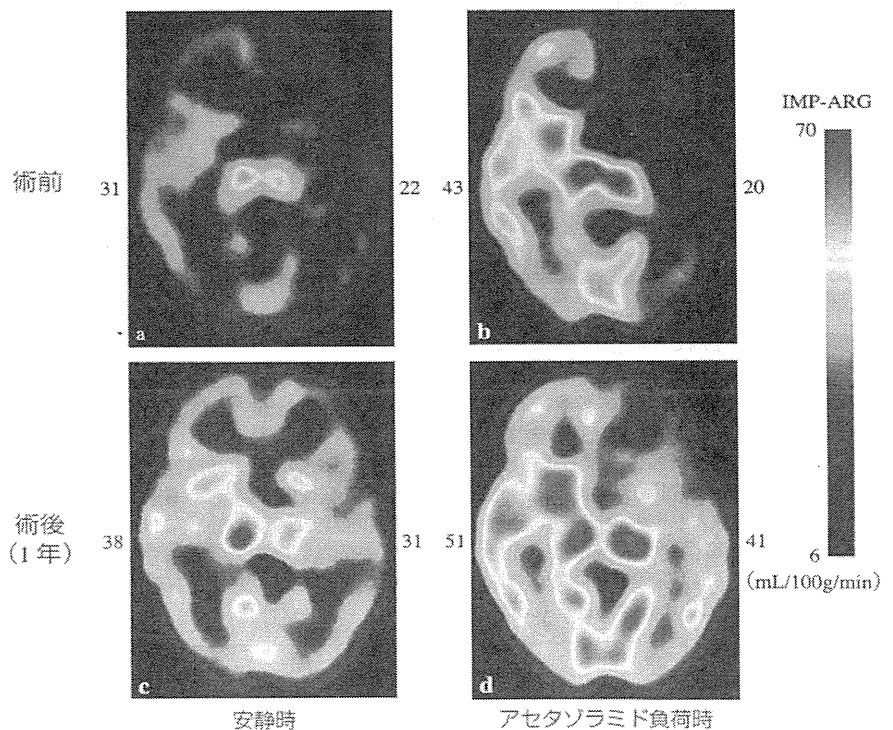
急性期の進行性脳卒中例の脳血流 SPECT 定量画像解析
